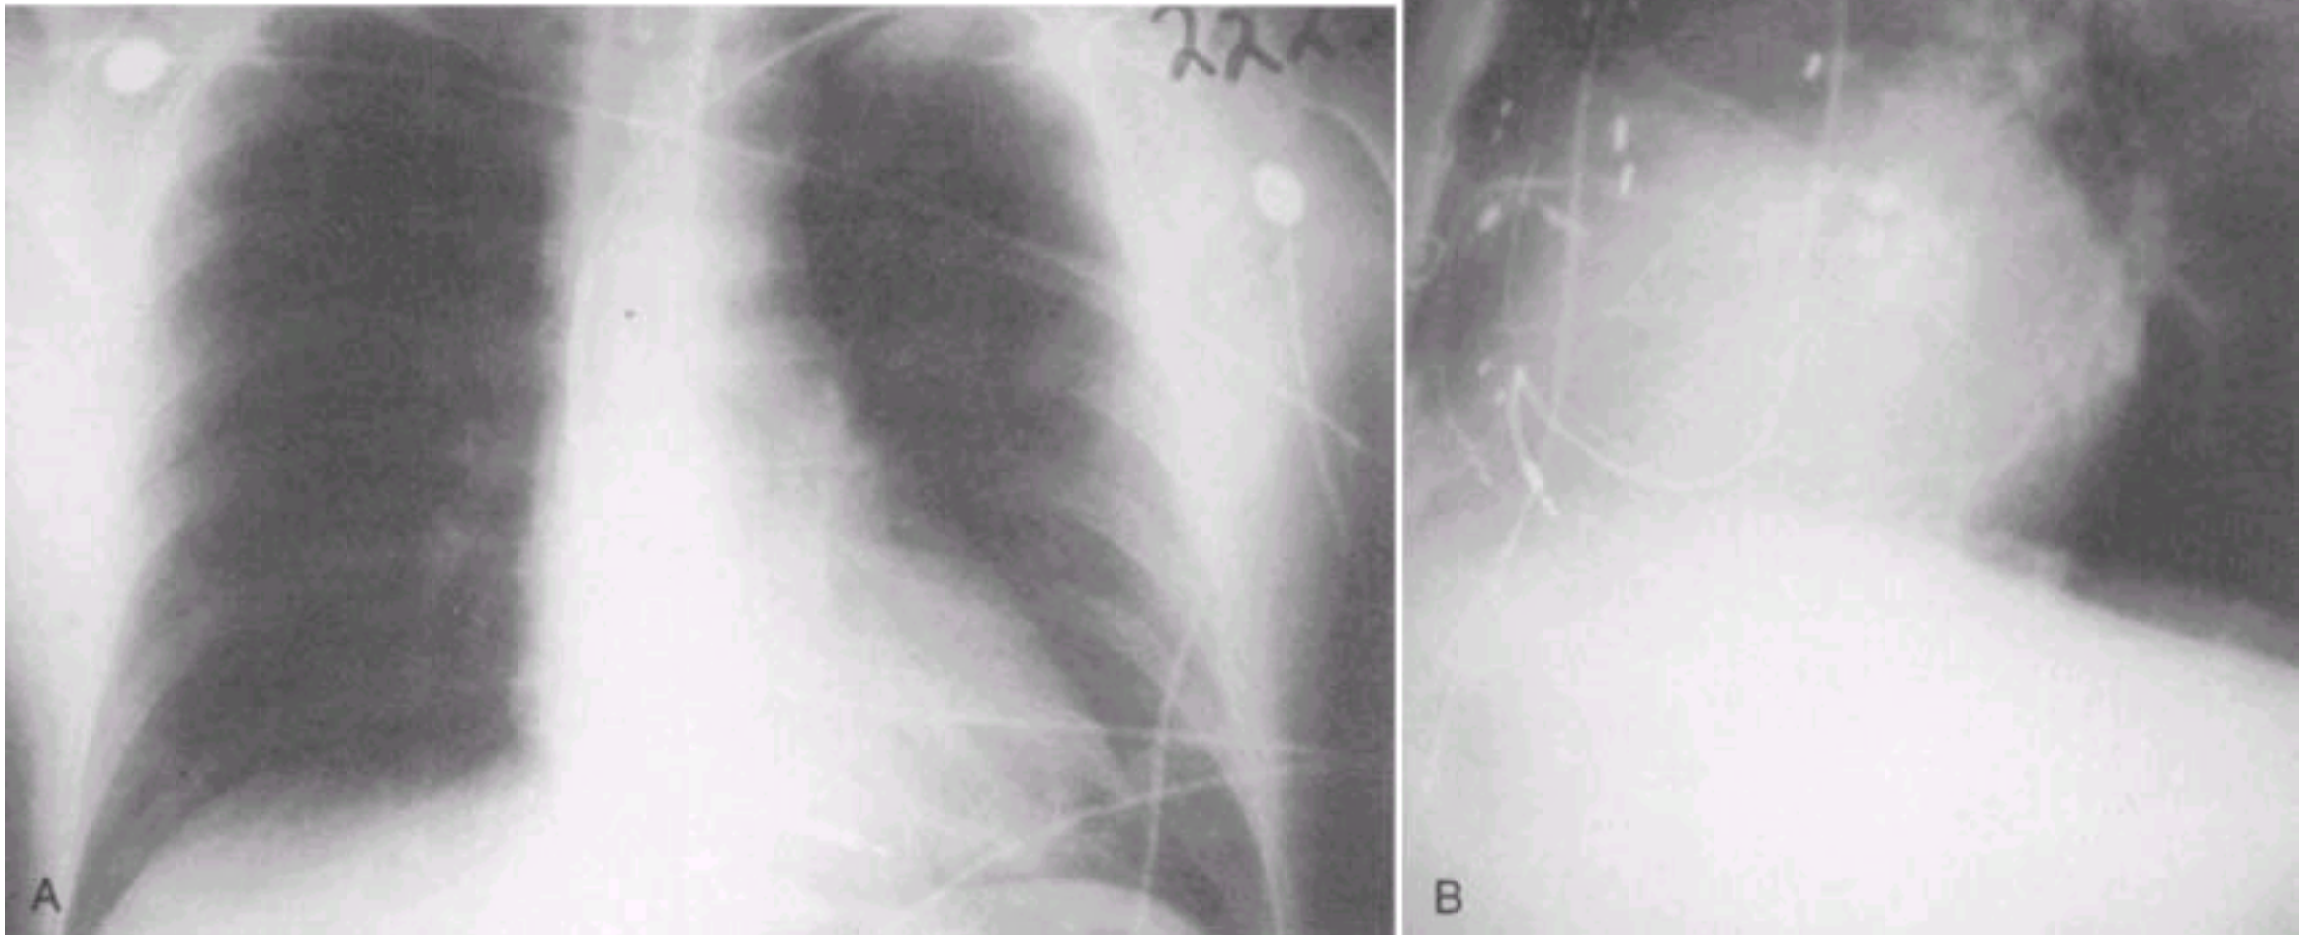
Posteroanterior (A) and lateral (B) chest radiographs demonstrating typical appearance of single-lead transvenous AICD.
